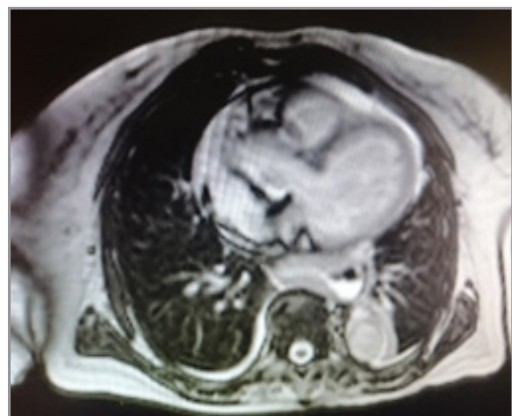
MRI compatible with resolving Takotsubo
